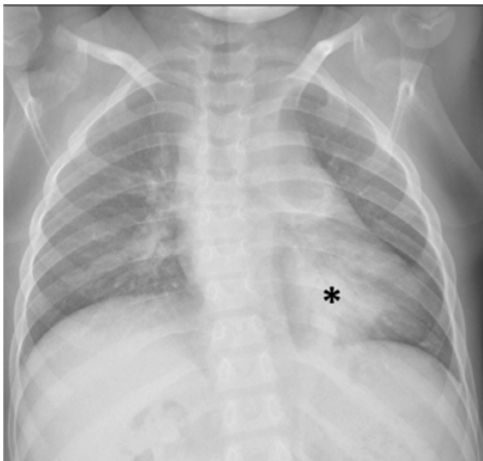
A case of 15-year-old female with asthma and positive COVID-19 RT-PCR test who presented with fever and respiratory distress. Chest radiograph shows ground-glass opacities in both peripheral (asterisk) and central (arrow) distribution, which are indeterminate CXR findings of pediatric COVID-19 pneumonia. Also noted is right apical pneumothorax⁷⁶
